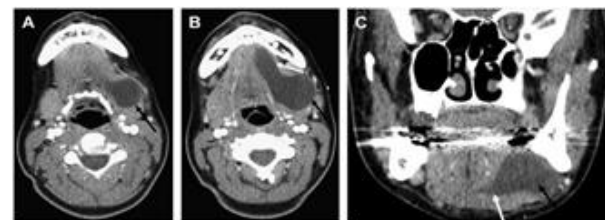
Diving ranula. Axial and coronal ontrast-enhanced CT images reveal a cystic lesion in the submandibular region (black arrows) with a tail-like extension (white arrow) into the sublingual space.
